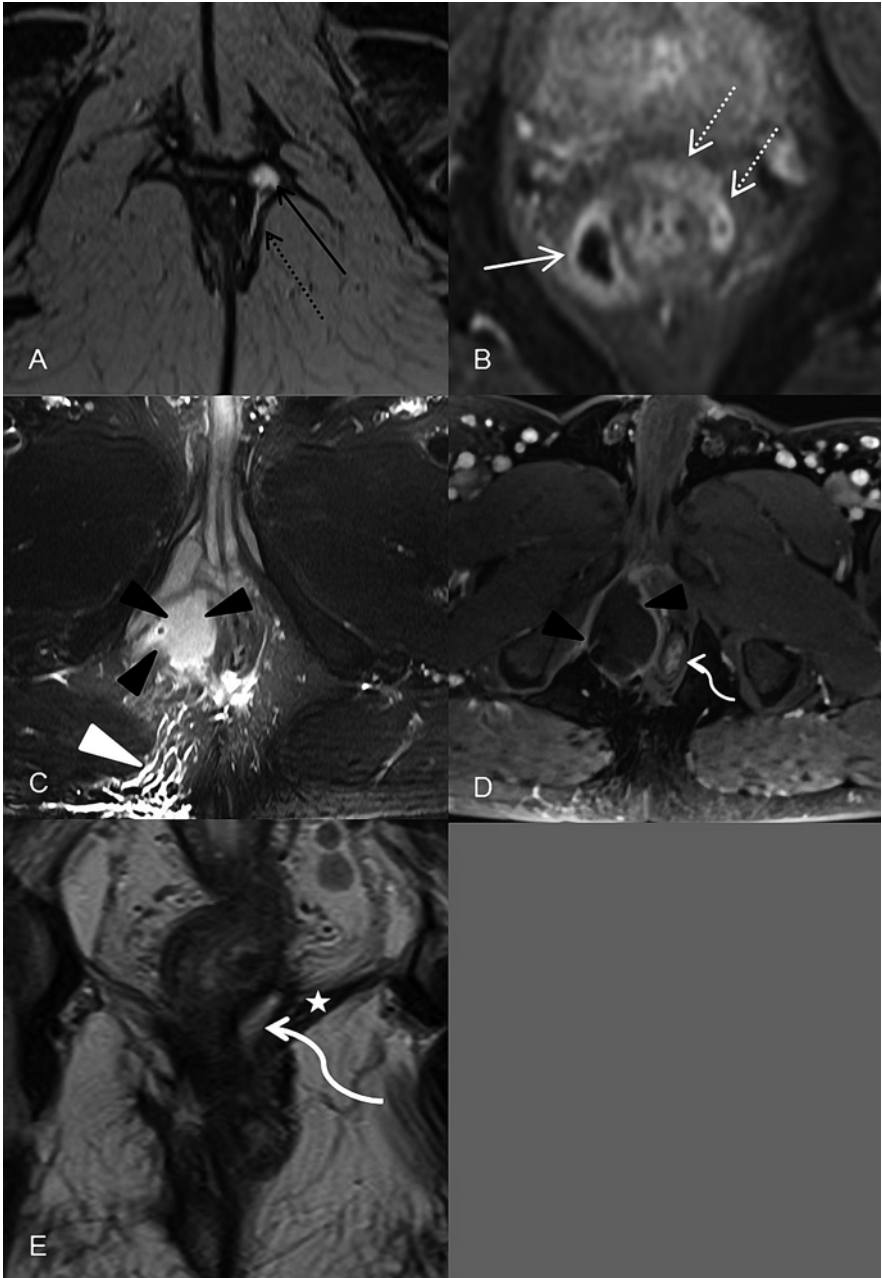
Axial T2-weighted MR image (a) shows a perianal abscess (*black arrow*) and associated fistula (*dashed arrow*). Axial T1 contrast-enhanced image (b) from a different patient with an intersphincteric abscess (*white arrow*). The associated, peripherally enhancing intersphincteric fistula tract is also seen (*dashed white arrows*). Axial T2-weighted image with fat saturation (c) shows a rounded ischioanal fluid signal abscess (*black arrow heads*). Ill-defined fluid signal in the surrounding ischioanal subcutaneous tissues (*white arrow head*) is compatible with edema. Axial T1 contrast-enhanced image (d) in the same patient shows peripheral enhancement of the abscess (*black arrow heads*) which exerts mass effect on the adjacent anus (*curved white arrow*). Coronal T2-weighted image in a different patient (e) with a supralelevator abscess (*curved white arrow*). The left levator is indicated by the *white star*
